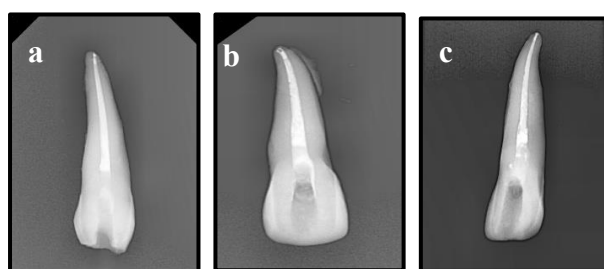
Tooth Sample Radiograph after placing the Intraorifice Barrier
